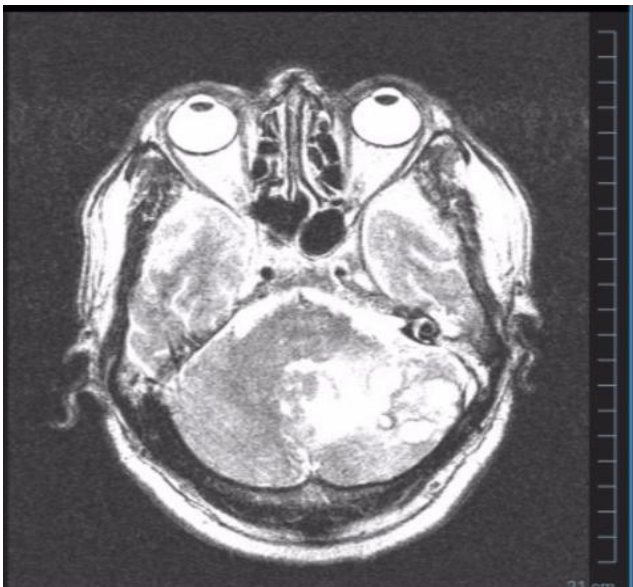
Head MRI. Multiple hypointense lesions in the left cerebellar hemisphere of T1W1, hypertense on T2W1 and restricted to DW1, with contrast enhancement rim. The lesion suppresses the IV ventricle
